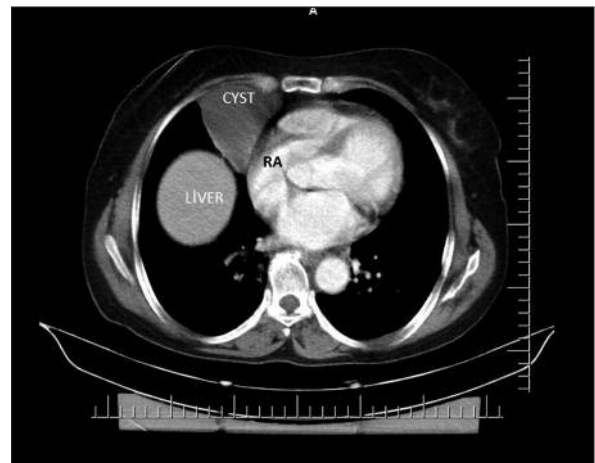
Thorax computed tomography (CT) scan showed that 6.0x5.0 cm sized mass at the right anterolateral side of the heart.
